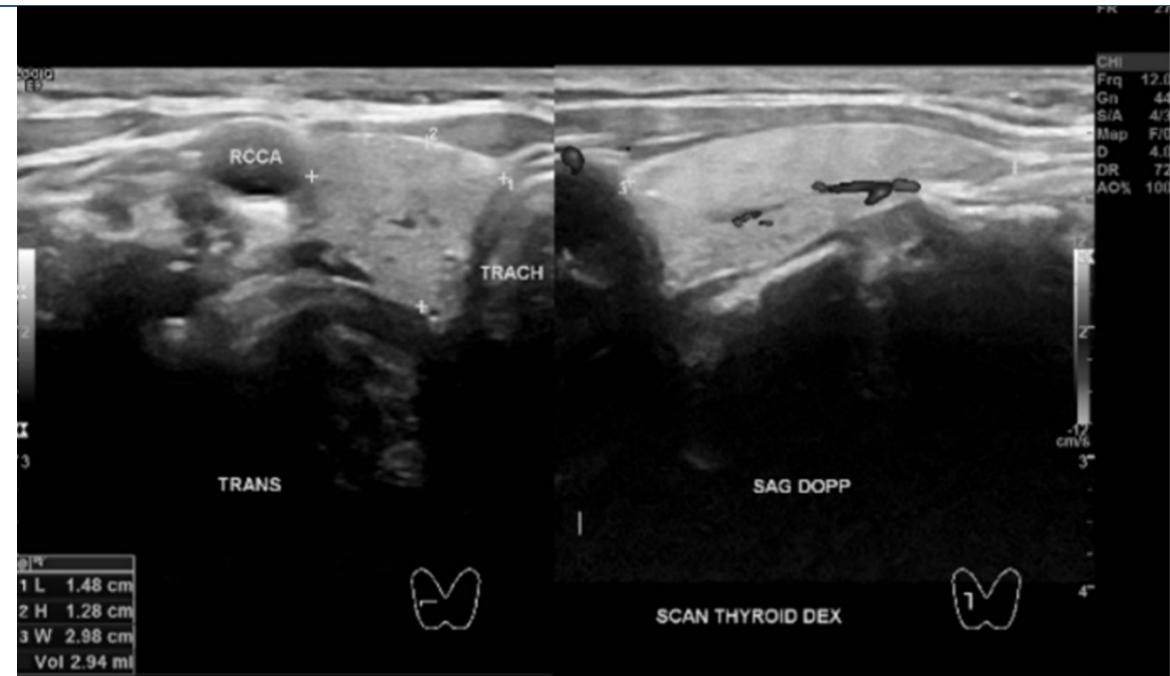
Neck ultrasound (USG) showing a spongiform, inhomogeneous lesion in the middle of the right thyroid lobe (TIRADS 2). The lesion has smooth margins and is not clearly distinguishable from thyroid parenchyma, complicating initial localization of the suspected parathyroid adenoma
